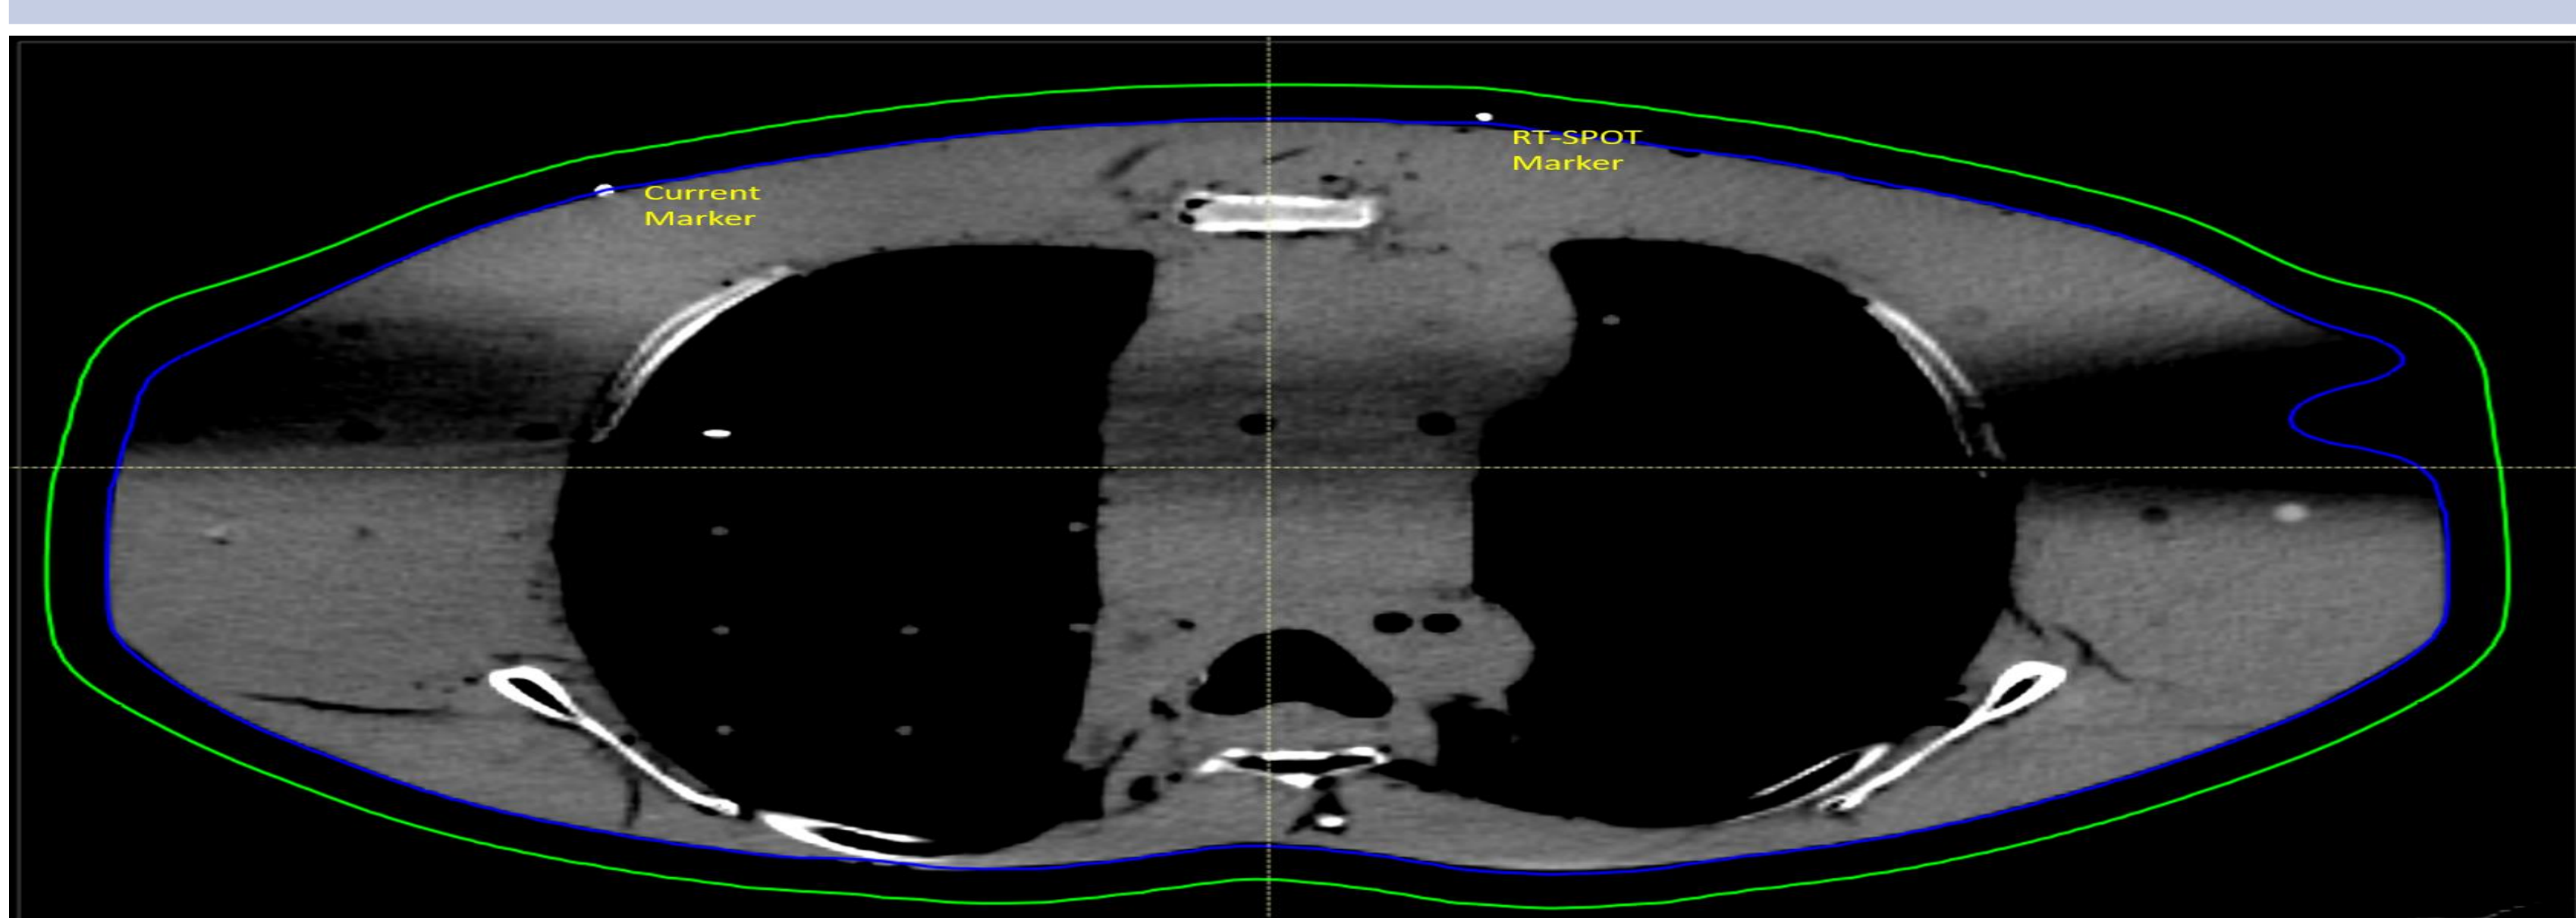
A representative slice of the CT image set, current marker on the right side and the RT-SPOT marker on the left side.
